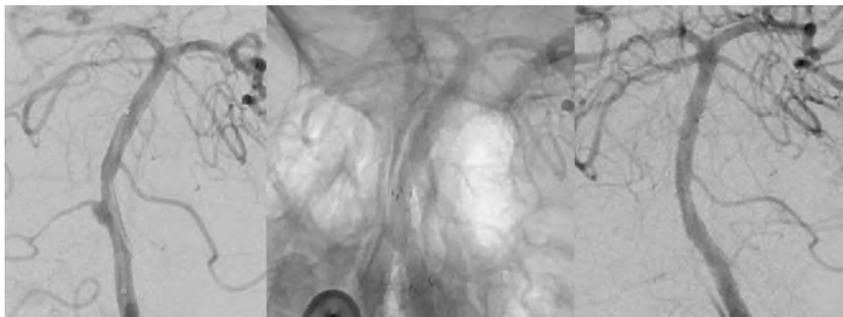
A 68-year-old male patient who had an SAH with a Hunt and Hess score of 3 (*left*). Diagnostic angiography reveals a 3-mm dissecting aneurysm of the basilar artery at the origin of the anterior inferior cerebellar artery (*middle*). Implantation of a FRED into the basilar artery with good wall apposition and complete coverage of the aneurysm neck and anterior inferior cerebellar artery origin was achieved. The patient was administered tirofiban for the first 24 hours after implantation (*right*). During recovery, the patient presented with cranial nerve IX to XII palsies and slight hemiparesis on the left. MR imaging showed only minimal DWI lesions in both cerebellar hemispheres (MRI not shown). Diagnostic angiography 7 days after the primary intervention revealed occlusion of the aneurysm and occlusion of the anterior inferior cerebellar artery. The patient recovered to a mRS 2 after 3 months.
